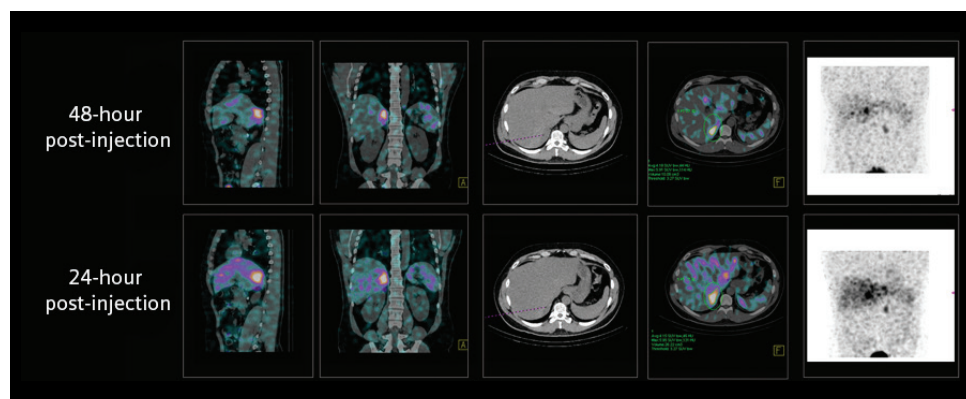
Sequential SPECT/CT images using xSPECT Quant acquired 24 hours and 48 hours after injection of 415 MBq of ^{123}I -MIBG to a patient with metastatic pheochromocytoma. Study shows tracer-avid liver metastases with SUV_{max} of 5.95 in the 24-hour image, which remains unchanged in the study acquired the next day (SUV_{max} of 5.91 in the 48-hour study). The normally functioning left adrenal gland shows similar focal uptake in both studies.
